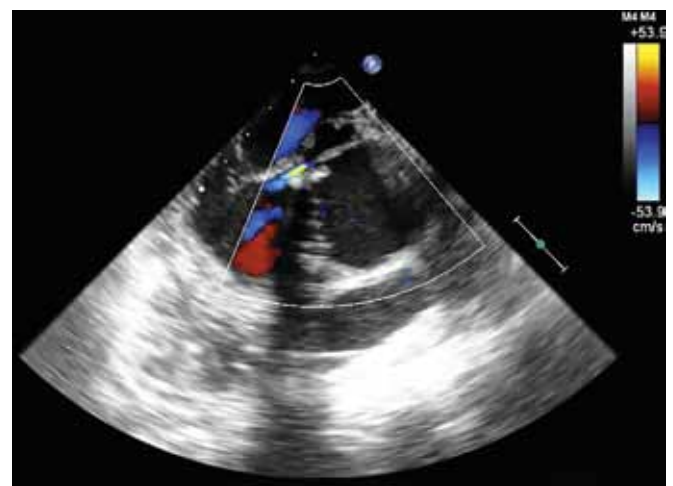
Transesophageal echocardiography, modified midesophageal long axis with color flow Doppler (diastole)
